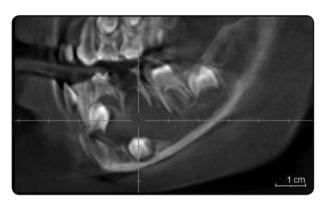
b) Pre-operative CBCT examination revealed a well-defined radiolucent area, the crown of 34 (FDI) involved in the radiolucent area while 35(FDI) displaced downward. by the cystic lesion.
